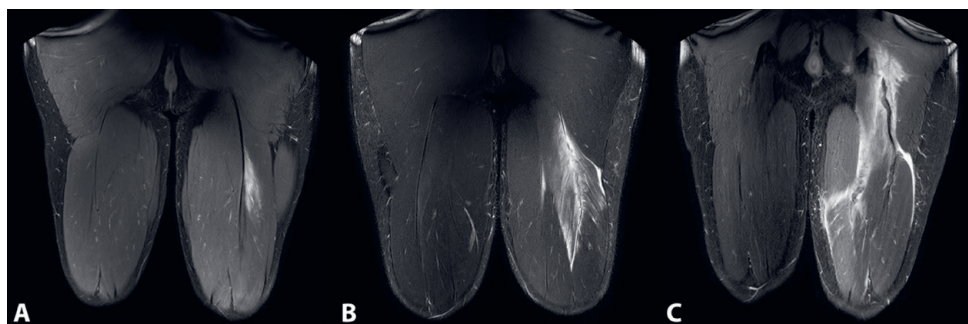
(A) Coronal MR image demonstrating injury at the musculotendinous junction (MTJ), (B) full-thickness intramuscular tendon injury, and (C) free tendon (avulsion) injury.
